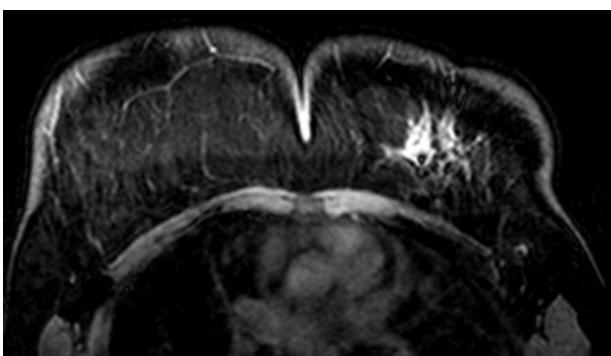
Post chemotherapy MRI.
